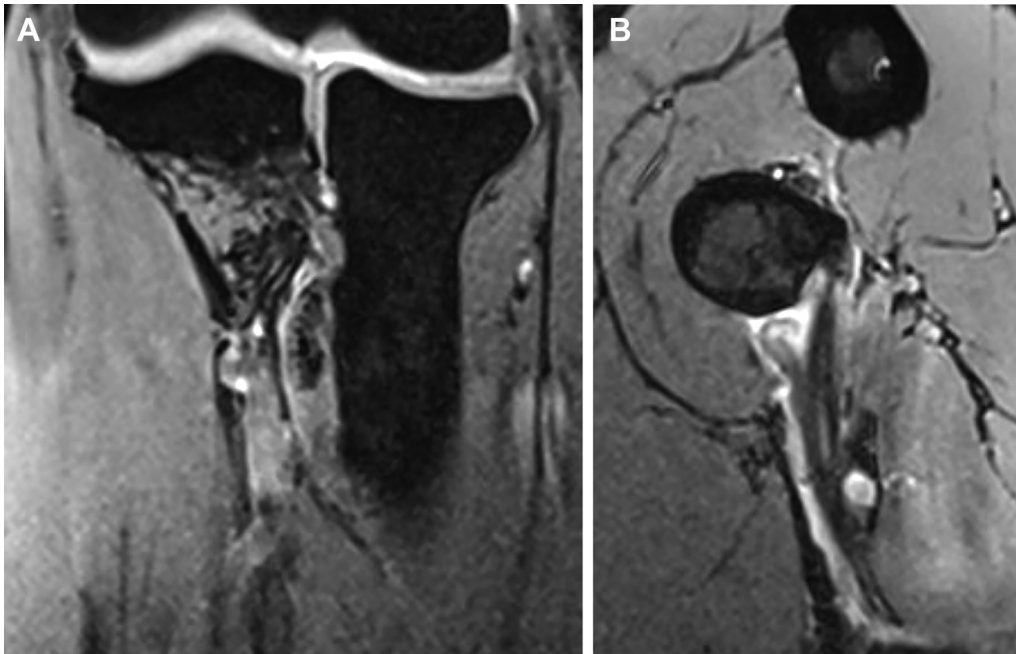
Flexion-abduction-supination magnetic resonance imaging views (3-dimensional double-echo steady-state with water excitation). (A) Intermediate-grade partial tear of distal biceps tendon with long head intact and short head tear. (B) Intermediate-grade partial tear of distal biceps tendon. Courtesy of MoRe Foundation.
